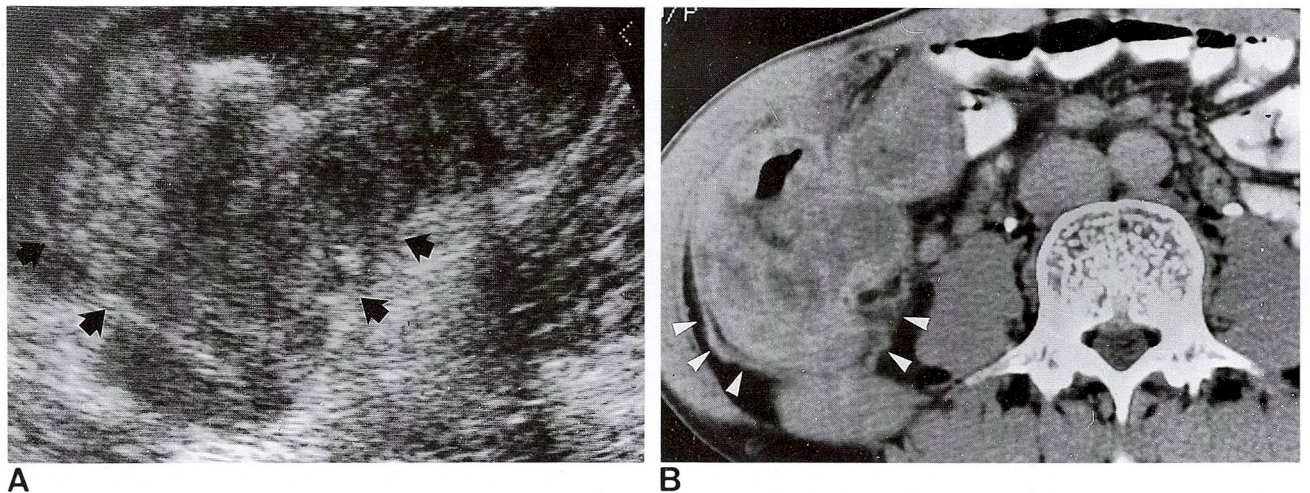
A 54 year old man with right lower quadrant pain. A. The ultrasonogram shows bowel wall obliteration and mixed echogenic mass with irregular margin and eccentric contour (arrows). B. The CT scan shows thickened bowel wall and heterogeneously enhancing mass with eccentric contour and perilesional fat changes (arrowheads). This case was ascending colon cancer.
